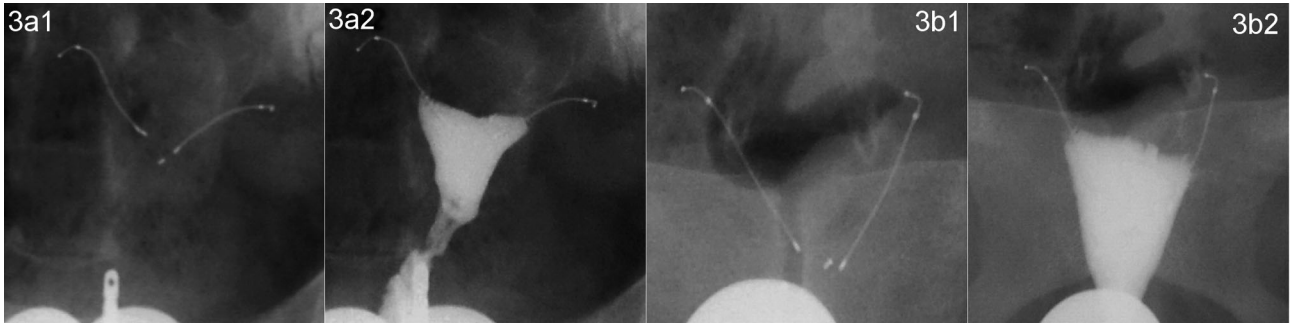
3a1-2, 3b1-2: Direct X-ray and HSG views showing too proximally located microinserts bilaterally belonging to two different patients. No passage can be seen in HSG views.
